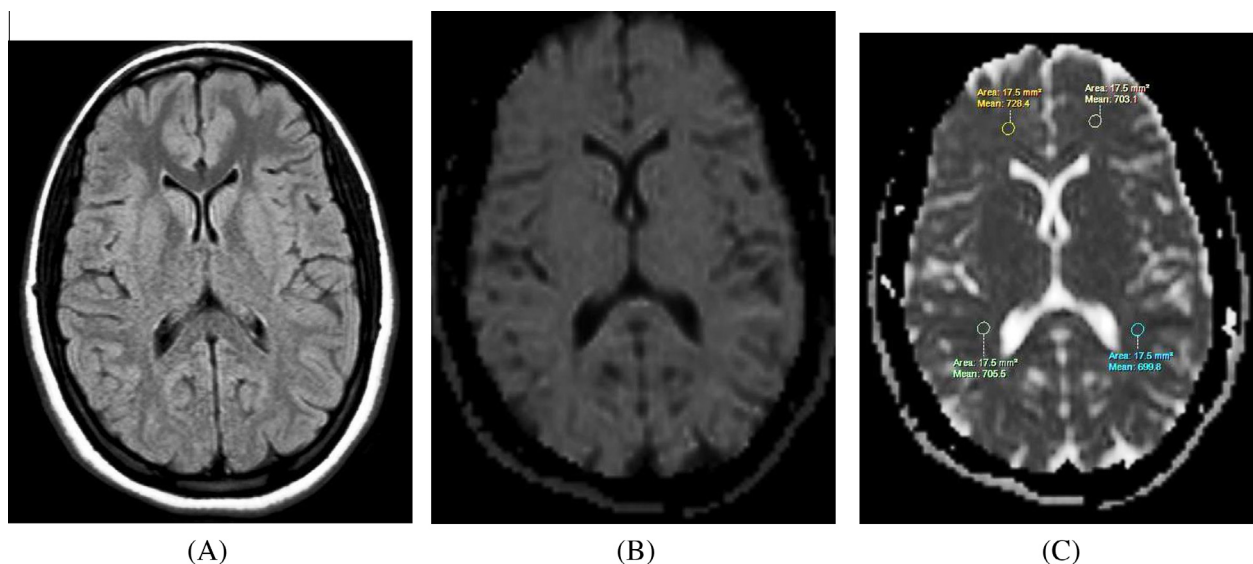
32 years old female healthy control subject with MOCA score 28. (A) FLAIR, (B) DWI, and (C) ADC showed normal white matter signal intensity. Quantitative ADC values of NAWM were 0.7284×10^{-3} , 0.7055×10^{-3} , 0.7031×10^{-3} , and $0.6998 \times 10^{-3} \text{ mm}^2/\text{s}$.
